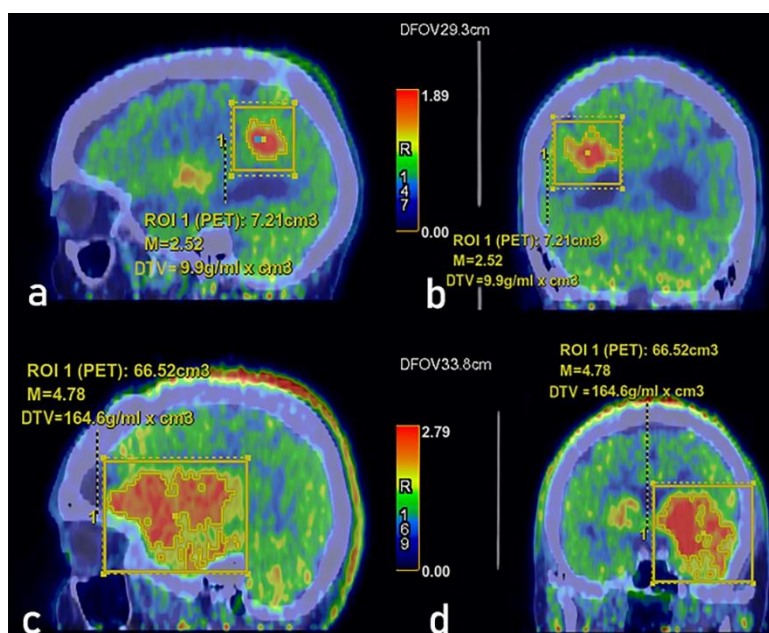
Total FDOPA activity of dopaminergic tumor volume (shown as DTV in the figure) and lesions on a dedicated workstation for calculation (version 4.4, Advantage Workstation, GE Healthcare, Chicago, Illinois) (shown as M in the figure); sagittal (a) and coronary (b) views of glioma II Patients, and glioblastoma IV in sagittal (c) and coronary (d) views of a patient. DTV and TLDA values correlate with SUVmax (see text).
